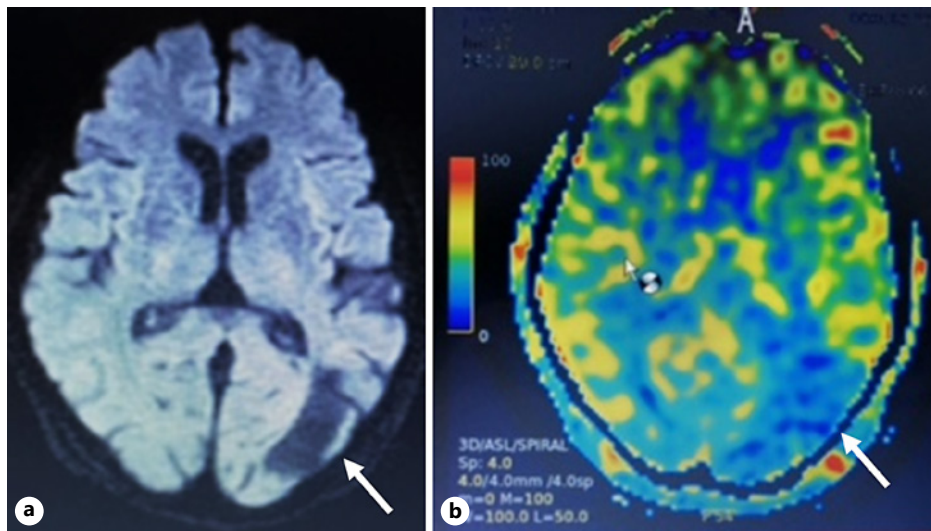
a MRI image performed at the neurosurgical hospital revealing a left obsolete occipital lobe infarction (arrow). b ASL image showing decreased blood flow in the same region (arrow). ASL, arterial spin labeling; MRI, magnetic resonance imaging.
